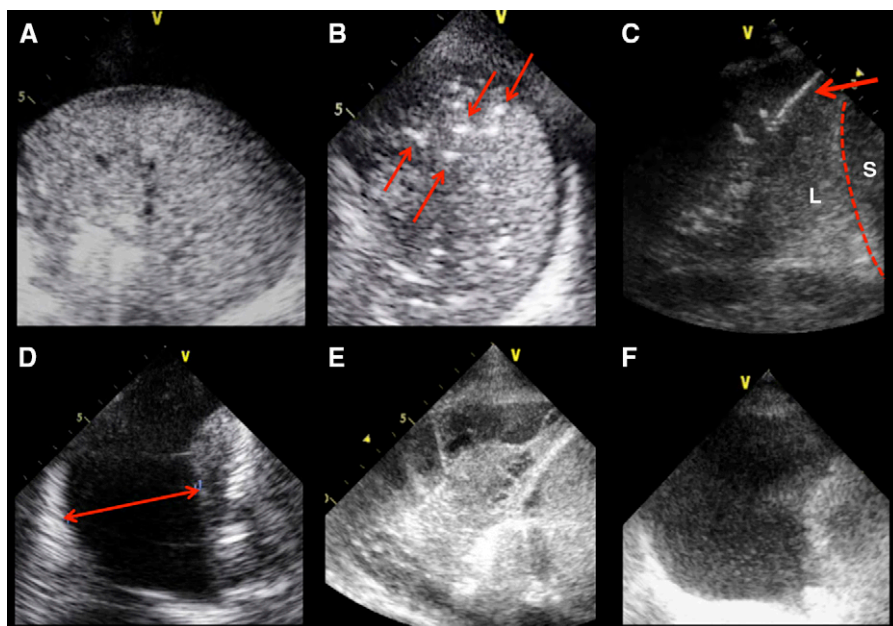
(A–C) Lobar consolidations are visualized as a tissue-like pattern; the air bronchograms are visualized as hyperechoic signs within consolidation and provide additional information on consolidation etiology. (A) The consolidated lung is visualized in transversal scan. It is homogeneously gray: air bronchogram is absent, which means airway is not clearly patent. Disobstructive fiber bronchoscopy may be indicated; no final conclusions on consolidation etiology can be drawn. (B) Multiple white spots (red arrows) are visualized within the consolidated lung in transversal scan and move synchronously with tidal ventilation: dynamic air bronchogram rules out obstructive atelectasis. (C) A dynamic linear/arborescent air bronchogram is specific for community-acquired and ventilator-associated pneumonia (longitudinal scan; dashed red line, diaphragm; L = lung; S = spleen). (D–F) Ultrasound features of pleural effusions. (D) Pleural effusion is here visualized in transversal scan as an anechoic space between the lung (on the right) and the posterior wall of the chest (on the left); transversal scan allows the measurement of the maximal interpleural distance (red arrow) and the quantification of the fluid collection, providing information about adequacy of chest drainage. Its homogeneous anechoic pattern orients to transudate; the lung appears partially consolidated. (E) Septa and adhesions are visualized within the pleural effusion in transversal scan: a phlogistic etiology is suggested, and septa discourage percutaneous chest drainage. (F) A massive echogenic pleural effusion is visualized in transversal scan between a collapsed lung (on the right) and the posterior wall of the chest (on the left); the nonhomogeneous pattern orients to exudate or blood (depending on clinical context); chest drainage is indicated.
